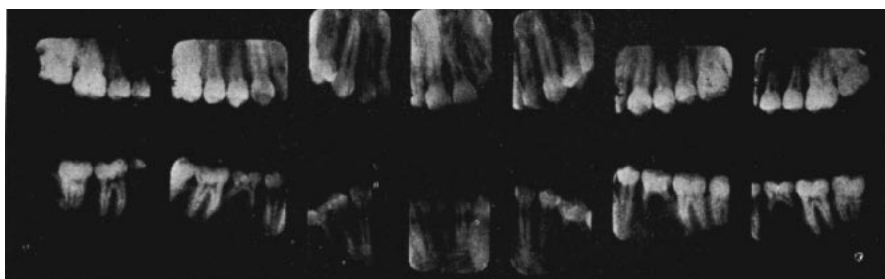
Radiographs of Case I after completion of active treatment.
